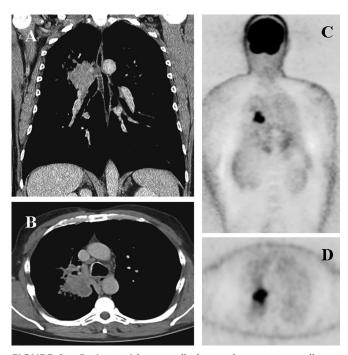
Patient with centrally located squamous cell carcinoma originating from the right upper lobe (A and B). Although PET shows only one area of increased FDG uptake without the suggestion of mediastinal lymph node metastases (C and D), a mediastinoscopy is indicated to rule out adjacent lymph nodes.
